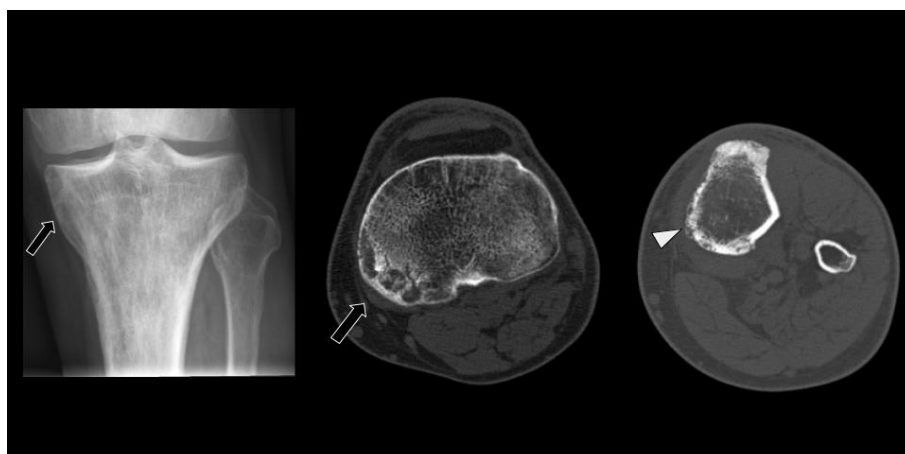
X-ray and computed tomography scan of the leg. Thickening of the anterior cortex of the tibia with patchy areas of reduced intracortical density (white arrows).
